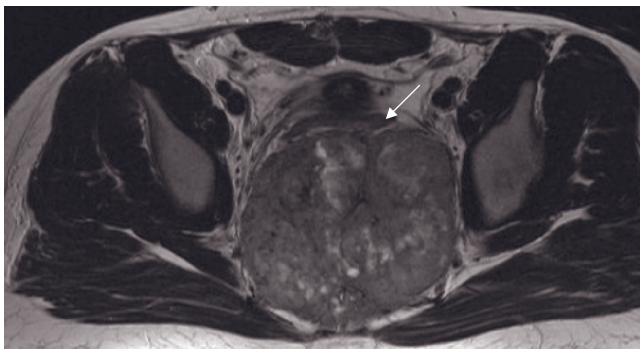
Extensive Ewing sarcoma of the pelvis. T2-weighted fat-suppressed echo-train spin-echo (*a*) and gadolinium-enhanced fat-suppressed SGE (*b*) images. An extensive heterogeneous mass originating from the left iliac bone is demonstrated. The mass invades all the muscles of the left pelvis and displaces the bladder (*b, a, b*) to the right. The tumor is heterogeneous with mixed high-signal-intensity areas on the T2-weighted image (*a*) and demonstrates heterogeneous enhancement after gadolinium administration (*b*). Chordoma. Transverse (*c*) and sagittal (*d*) high-resolution fast spin-echo T2-weighted, T1-weighted postgadolinium
